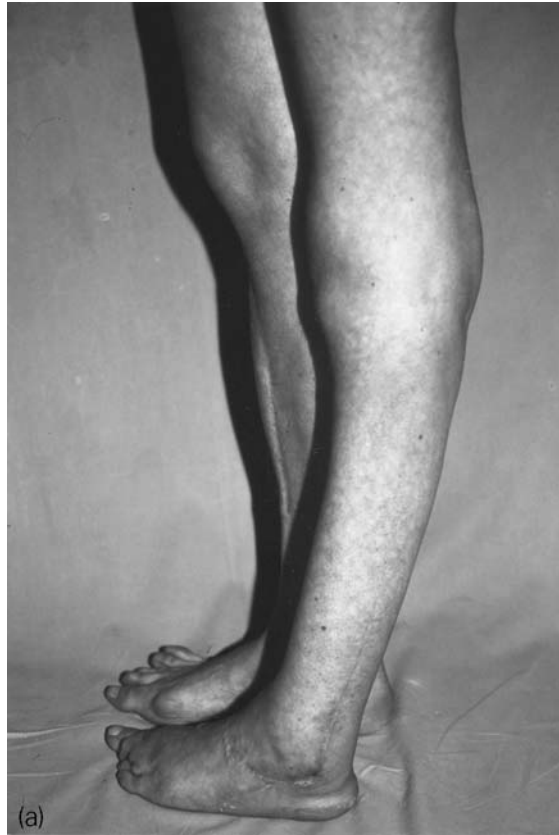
A 38-year-old woman with the outcome of poliomyelitis of the lower left limb. The patient underwent tibio-talar, talar, and midfoot arthrodeses at the age of 14. (a) Residual valgus-recurvation of the knee, mildly supinated equinus foot, and adduction of the forefoot. (b) Medial clinical photograph showing the equinus. (c) Lateral radiograph before treatment showing equinus of the foot. (d and e) Treatment plan. (f) Radiograph of the foot during treatment. (g) Clinical photograph showing the correction of the leg deformity and adduction of the foot. (h) Photograph of the foot showing the clinical result of correction of equinus.
